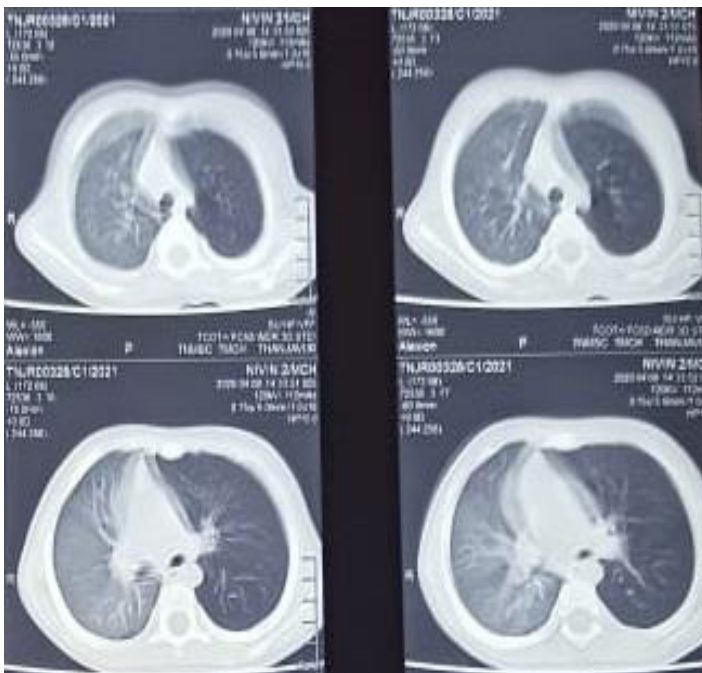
CT Chest image showing Hyperinflated lung in left side with tracheal shift to right side
